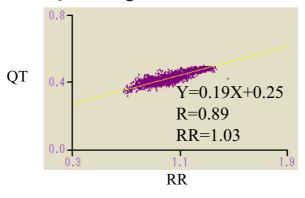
Representative QT-RR relationship in a 65-year-old woman with cardioembolic stroke. MRI: magnetic resonance imaging, DWI: diffusion weighted imaging
